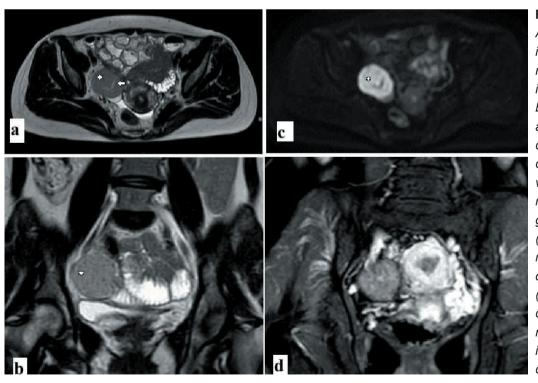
(a, b) A homogeneous intermediate ovarian mass (*) on T2W images, with a regular border. There aren't any signals suggesting cystic or hemorrhagic components. The vascular origin from the right internal iliac artery goes into the tumor (arrow), which showed restricted diffusion on DWI (c) and ADC (not shown). (d)After contrast, the tumor is mildly enhanced, which is lower enhanced compared to the uterus. The patient underwent a pelvic MRI which confirmed a right ovarian solid mass (Figure 2). Some diagnosis is considered including AGCT, fibroma, thecoma, Brenner tumor, or dysgerminoma.
